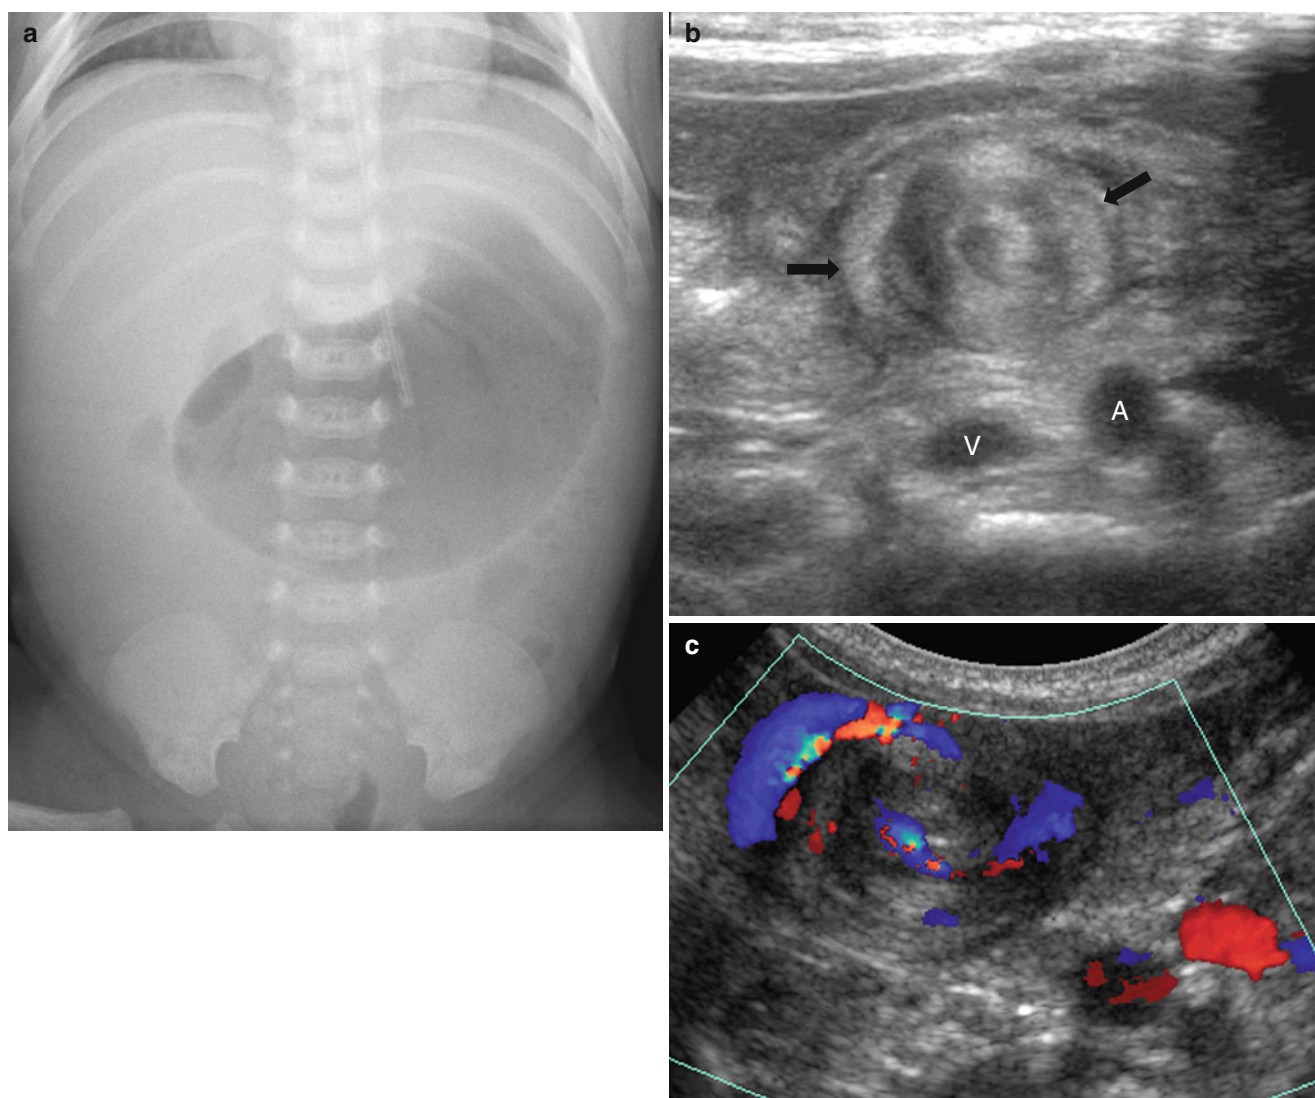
Midgut volvulus with Ladd band in a 1-month-old boy presenting with bilious vomiting. (a) Abdominal radiograph demonstrates the distended stomach and paucity of gas in the remainder of the bowel loops. (b) Transverse US of the upper abdomen shows a whirl-like mass
